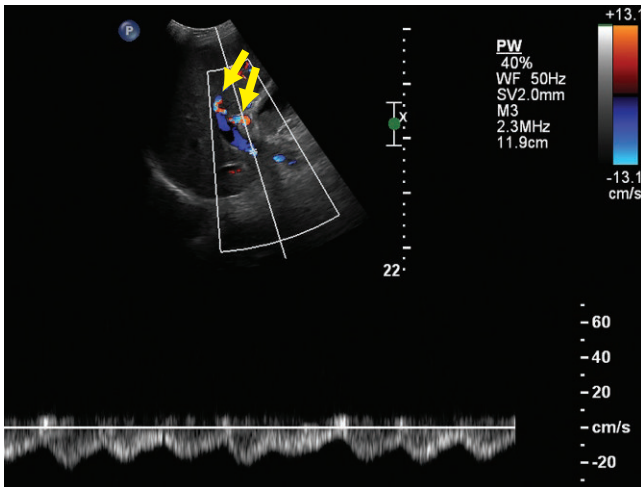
Color duplex of the porta hepatis demonstrates a blue portal vein (away from the transducer) with flow exiting the liver. This is confirmed by the spectral Doppler, which is also away from the transducer and hepatofugal. Hepatic arteries (arrows) are segmentally seen.
